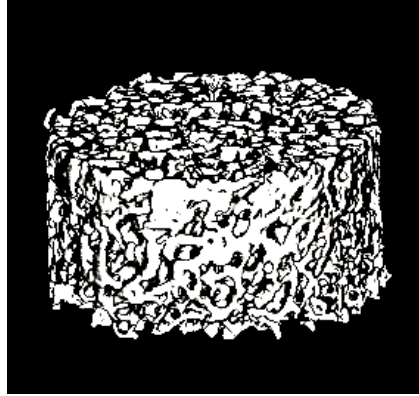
Micro CT scan of human trabecular bone core. Scan taken at the end of the ex vivo study.
